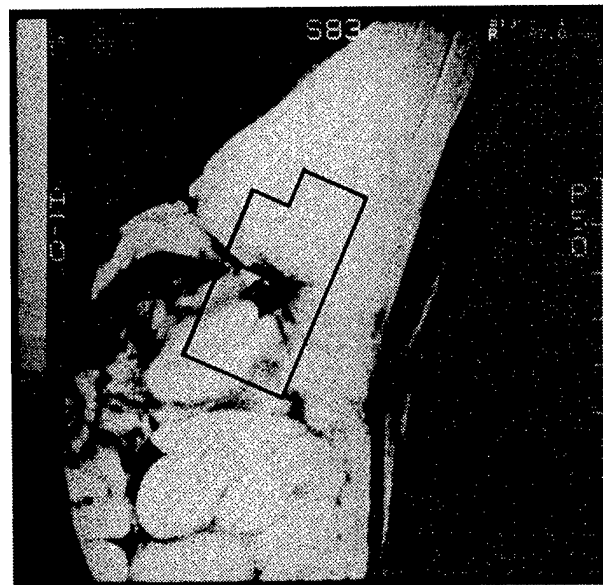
MRI of case 1, after a radiation therapy. The closed area shows the area that optical imaging was conducted (see Figure 5). The size of the seroma became reduced and formed a heterogeneous fibrotic mass after the irradiation.
